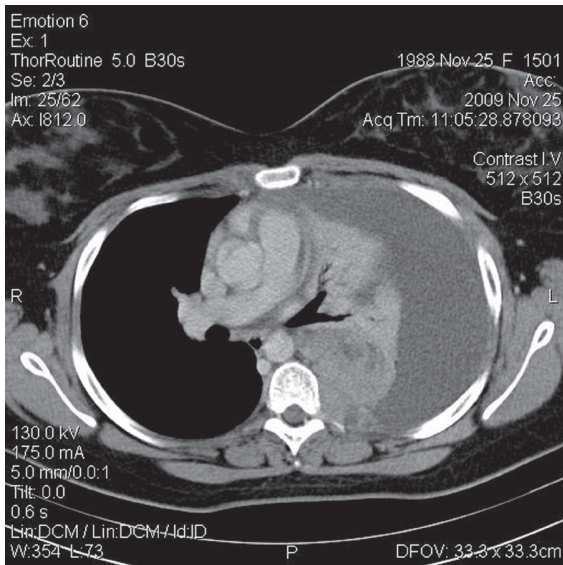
CT examination after contrast administration revealing a large pleural effusion and a heterogeneous, enhancing mass located at the left pleural cavity (a, b).
